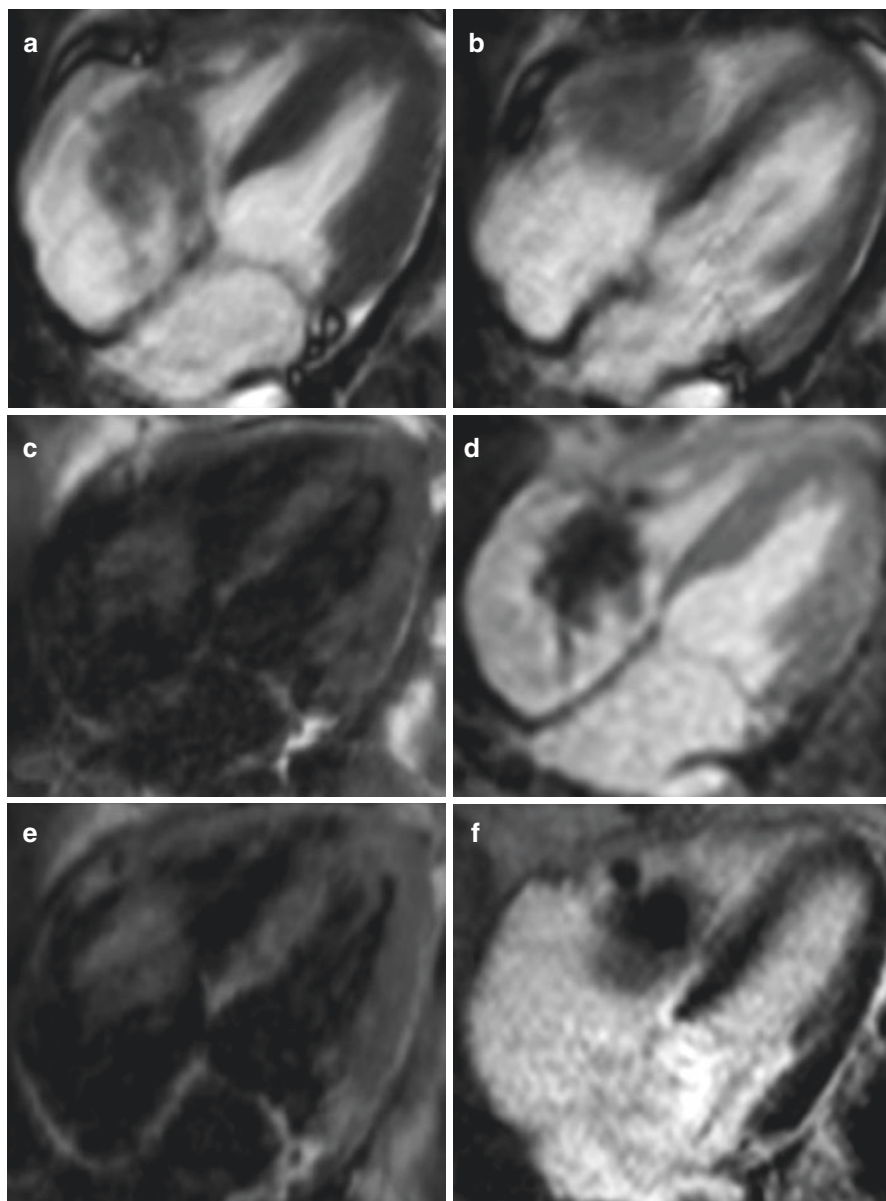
A 54 year old female patient with a sizable mobile tricuspid valve mass seen by echocardiography. CME images: (a–b) cine SSFP images in four chamber plane in systole and diastole, showing the mass behind attached to the posterior leaflet of the tricuspid valve with no signs on invasive behavior. It is rather mobile with leaflet excursion. (c–e) T1 pre- and post-contrast images, as well as (d) first pass perfusion and (f) LGE images show patchy mainly peripheral enhancement of the sizable mass. Overall features are suggestive of a tricuspid valve myxoma
